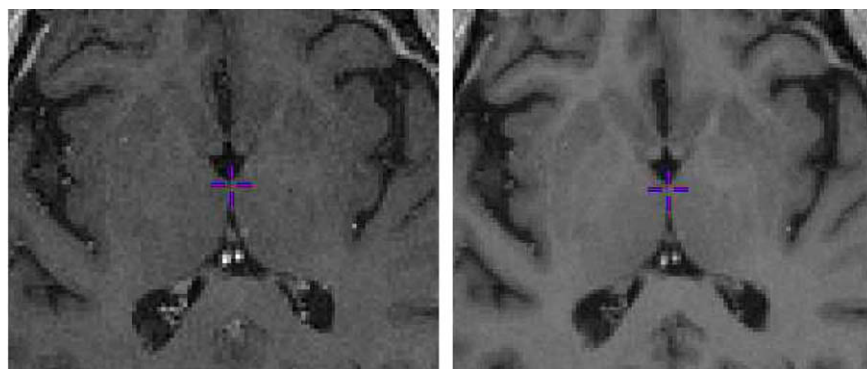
Example of data used for validation of warping techniques. (From left to right) Axial sections MRI volumes acquired with head-frame, and the average of a volume acquired with a head-frame and without a head-frame. Note the difference between resolution and contrast of the two volumes. Averaging the two volumes increases the ease for raters to properly identify the subcortical nuclei being assessed in Section 3.2.
